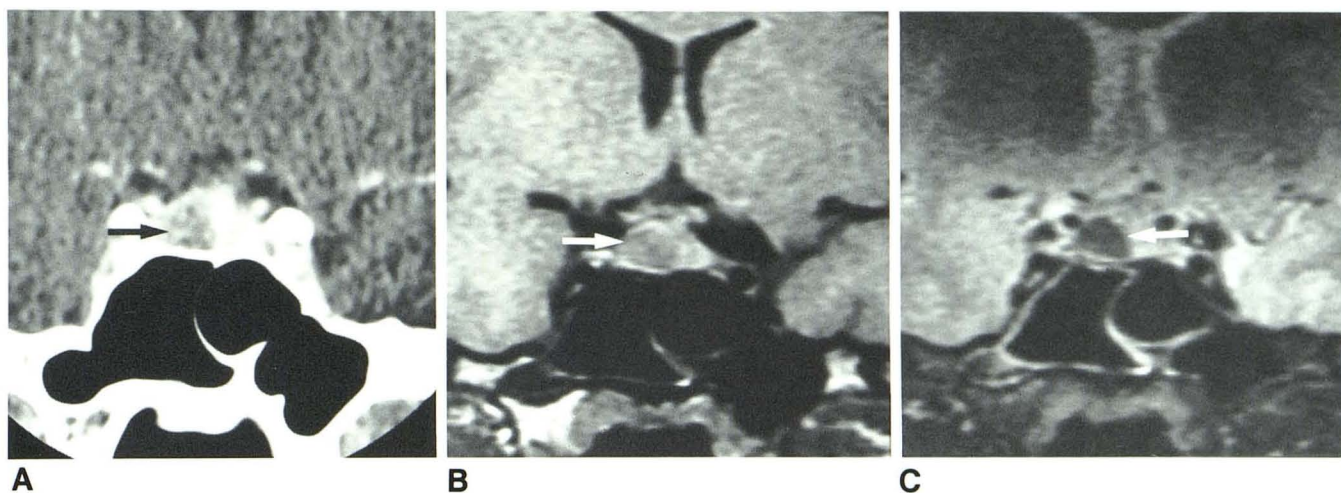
Subsequently proven microadenoma having long T1 and short T2. A, CT scan shows tumor (arrow). B, Short TR sequence (800 msec TR, 25
